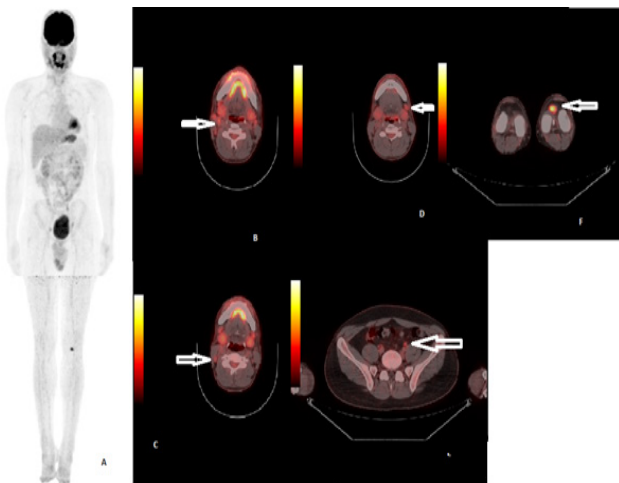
Latest 18F-FDG PET/CT scan A) MIP images, B-C-D-E) multiple lymph nodes, F) focal patellar uptake (white arrows).
